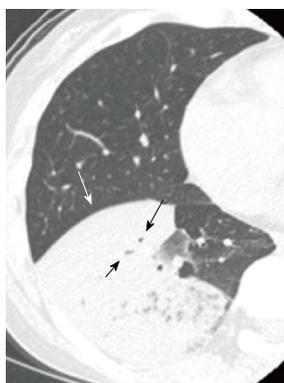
Invasive mucinous adenocarcinoma (formerly mucinous bronchioloalveolar carcinoma) in a woman in her 60s. Thin-section computed tomography shows a nonsegmental consolidation with a bulging fissure (white arrow) and narrowed air bronchograms (black arrows).
